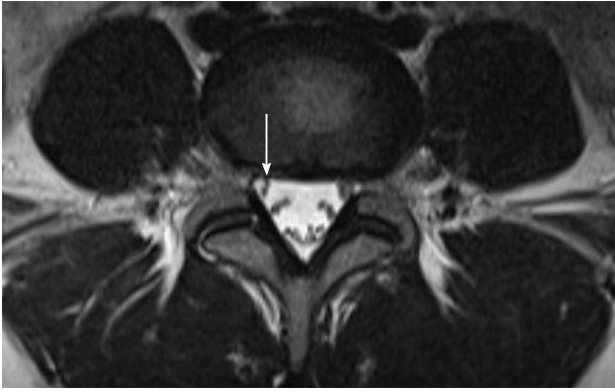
Axial T2-weighted magnetic resonance image of lumbar level L4/5 shows the lateral recess that is bordered laterally by the pedicle, posteriorly by the superior articular facet, and anteriorly by the vertebral body, endplate margin, and disc margin.
